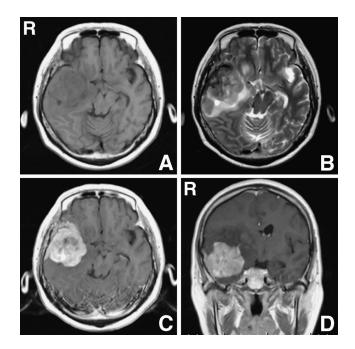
A: T_1 -weighted magnetic resonance (MR) image showing a hypointense lesion in the right temporal region. B: T_2 -weighted MR image showing an isointense lesion. C, D: T_1 -weighted MR images with gadolinium enhancement showing a heterogeneously enhanced mass with irregular margins (diameter, 50 mm).
